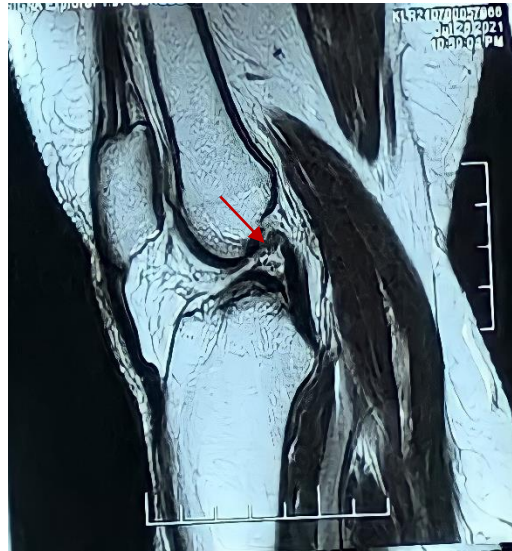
Image showing MRI findings of partial ACL tear (red arrows) but arthroscopy shows complete ACL tear (black arrows)
